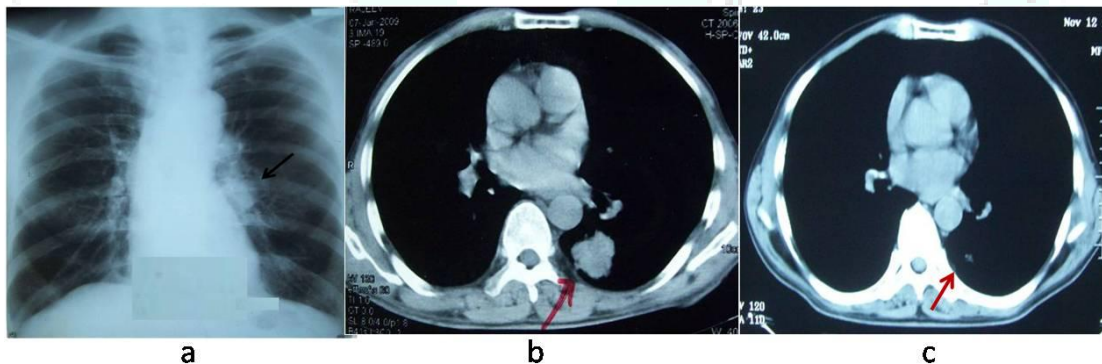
Admission chest x ray (a) showing prominent left hilum (arrow), computed tomography (b) revealing 4.4×4×3 cm nodular lesion in superior segment of left lower lobe (arrow) and post six cycles computed tomography depicting (c) residual lesion.
